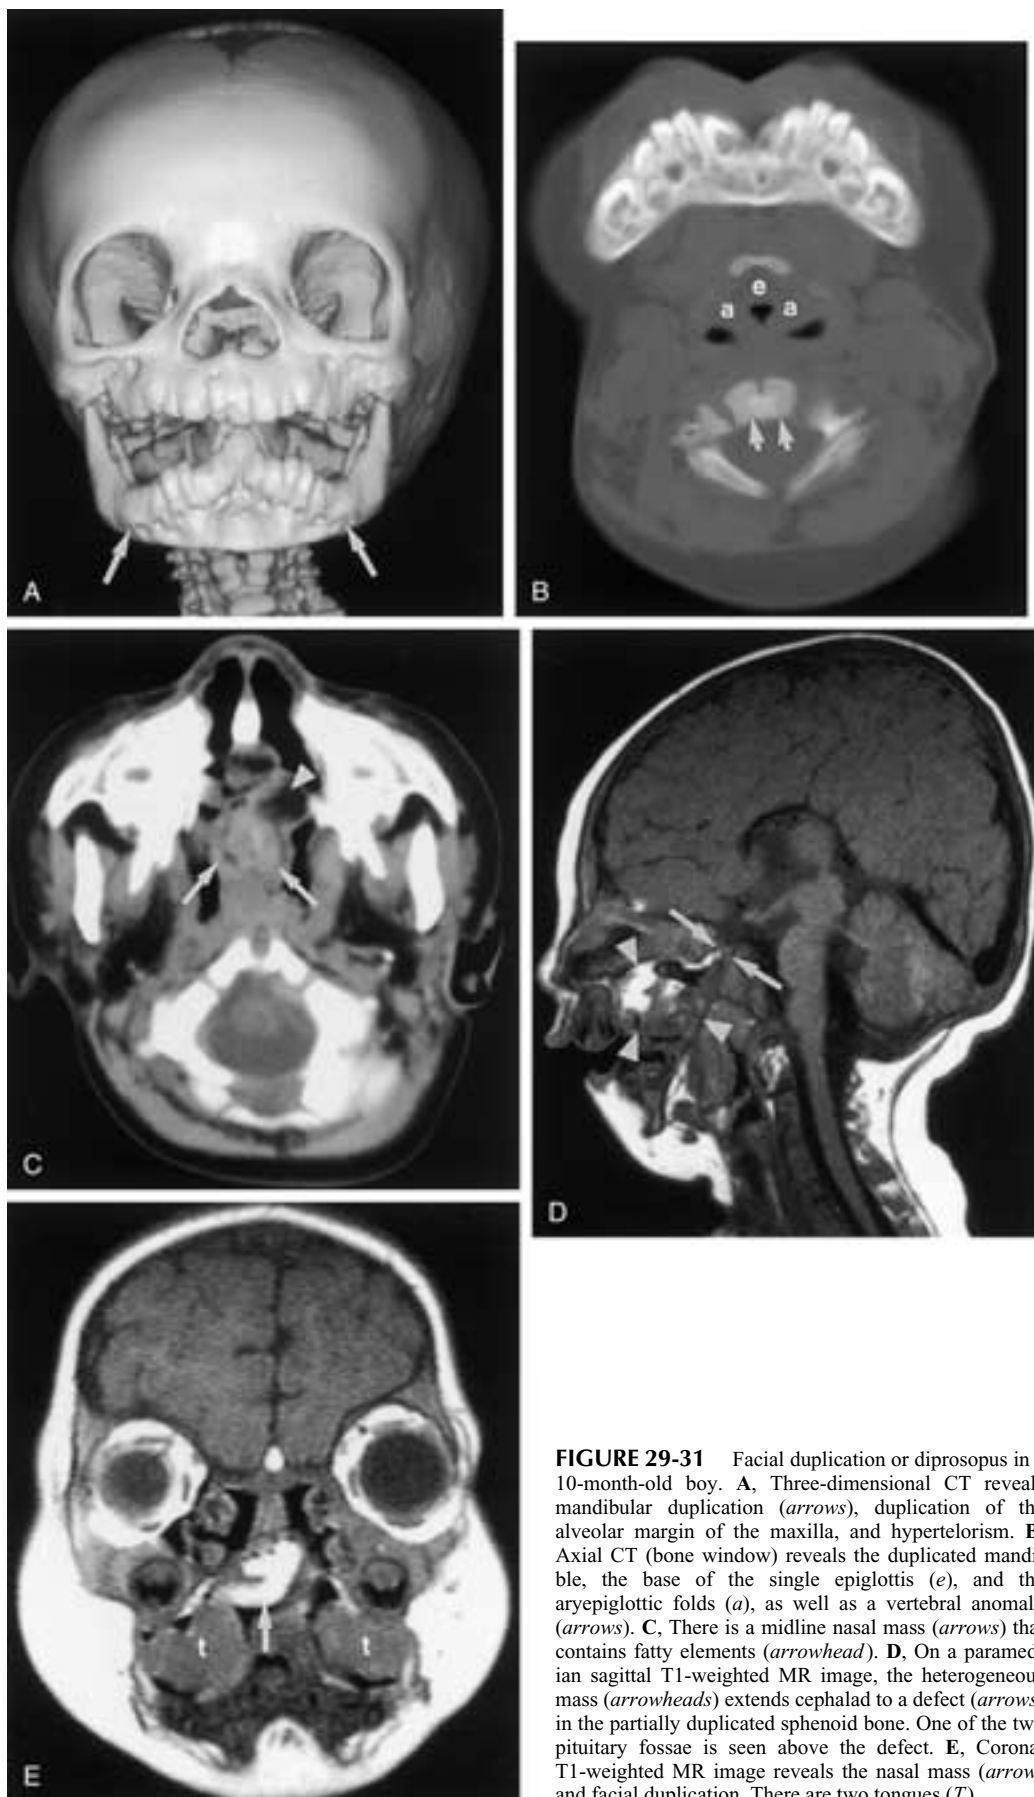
Facial duplication or diprosopus in a 10-month-old boy. A, Three-dimensional CT reveals mandibular duplication (*arrows*), duplication of the alveolar margin of the maxilla, and hypertelorism. B, Axial CT (bone window) reveals the duplicated mandible, the base of the single epiglottis (*e*), and the aryepiglottic folds (*a*), as well as a vertebral anomaly (*arrows*). C, There is a midline nasal mass (*arrows*) that contains fatty elements (*arrowhead*). D, On a paramedian sagittal T1-weighted MR image, the heterogeneous mass (*arrowheads*) extends cephalad to a defect (*arrows*) in the partially duplicated sphenoid bone. One of the two pituitary fossae is seen above the defect. E, Coronal T1-weighted MR image reveals the nasal mass (*arrow*) and facial duplication. There are two tongues (*T*).
